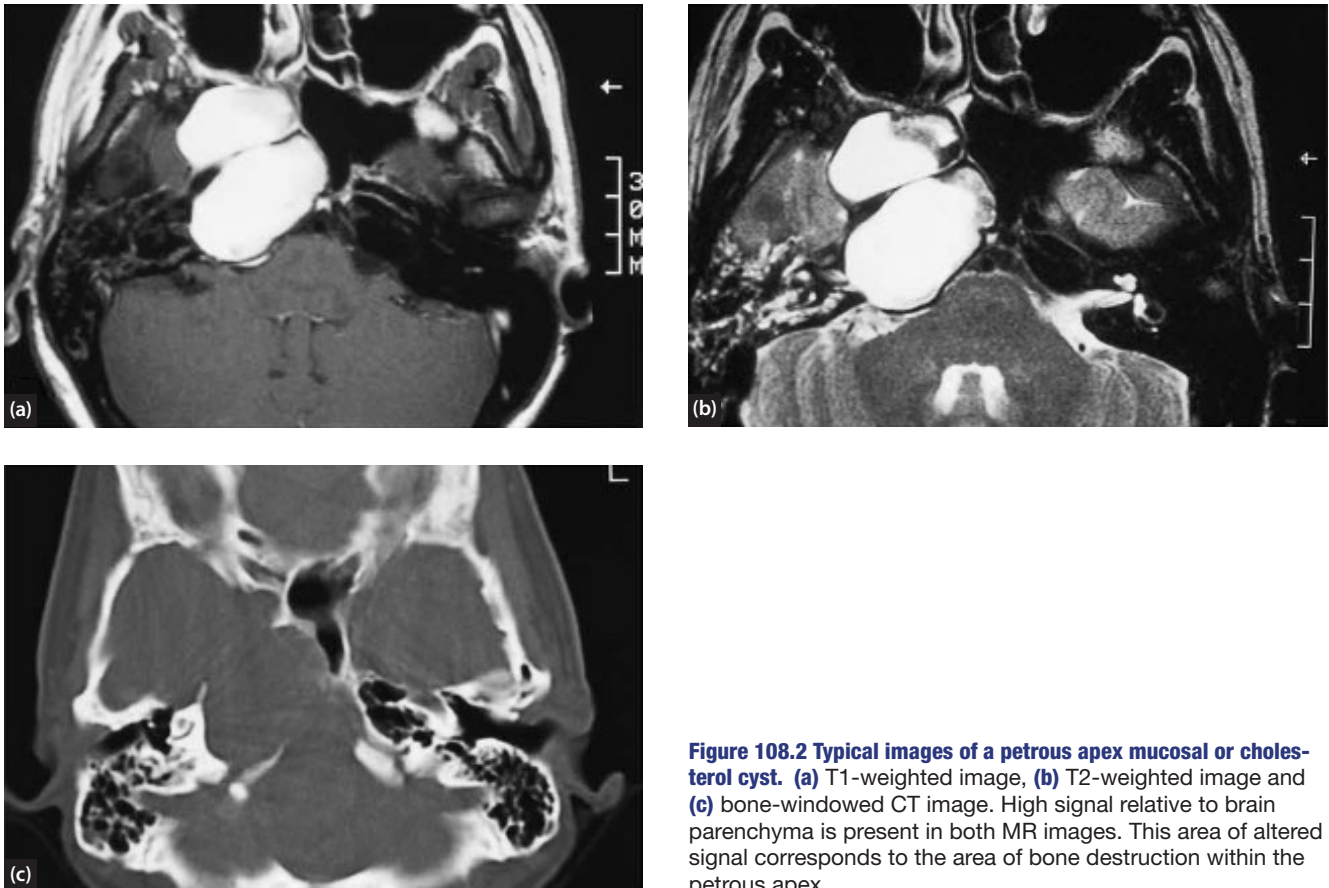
Typical images of a petrous apex mucosal or cholesterol cyst. (a) T1-weighted image, (b) T2-weighted image and (c) bone-windowed CT image. High signal relative to brain parenchyma is present in both MR images. This area of altered signal corresponds to the area of bone destruction within the petrous apex.
